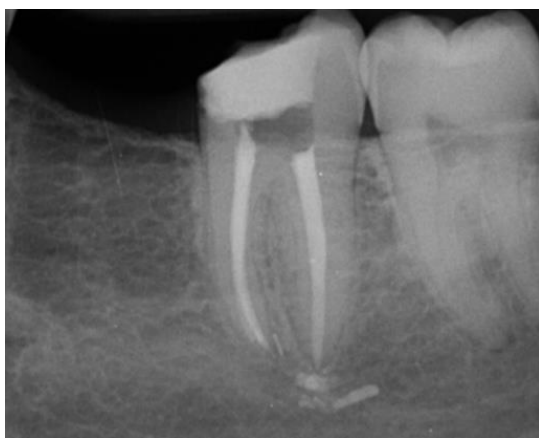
Thirty-six-month follow-up radiography demonstrated periapical lesion healing
